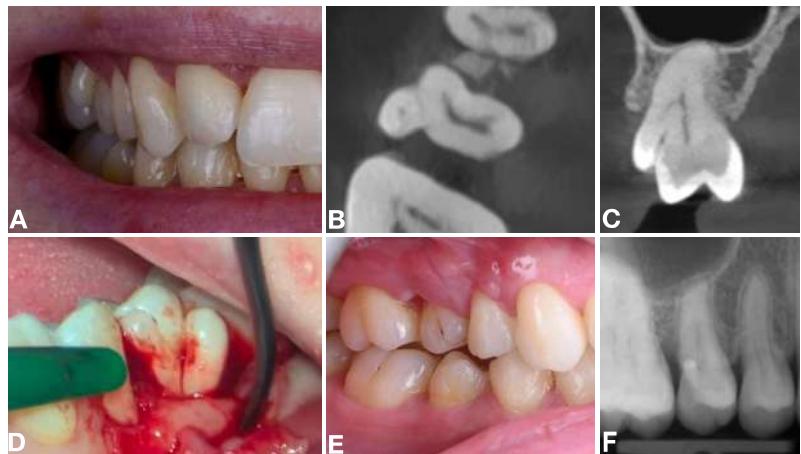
Preoperative intraoral photograph of the upper right second premolar (#15) (A), preoperative CBCT (B & C), raised two-sided flap to visualise the accessory cusp on tooth (D), 2-week postoperative photograph (E), and postoperative radiograph (F).
